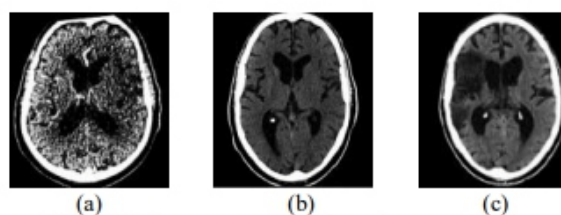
(a) Computed Angiography-Source Image (CTA-SI); (b) Non-Contrast CT (NCCT); (c) Ischemia on CTA-SI compared to NCCT
